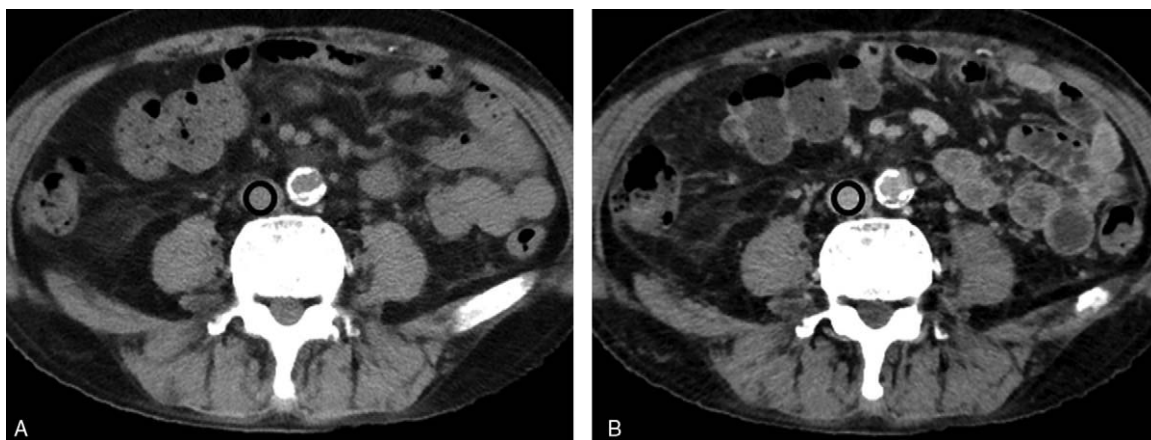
A and B show the precontrast CT and CT venography images above the level of the inferior vena cava (IVC) bifurcation. We measured the venous attenuation using circular regions of interest (ROIs) (ROI_{plain-IVC} and ROI_{CTV-IVC}).
